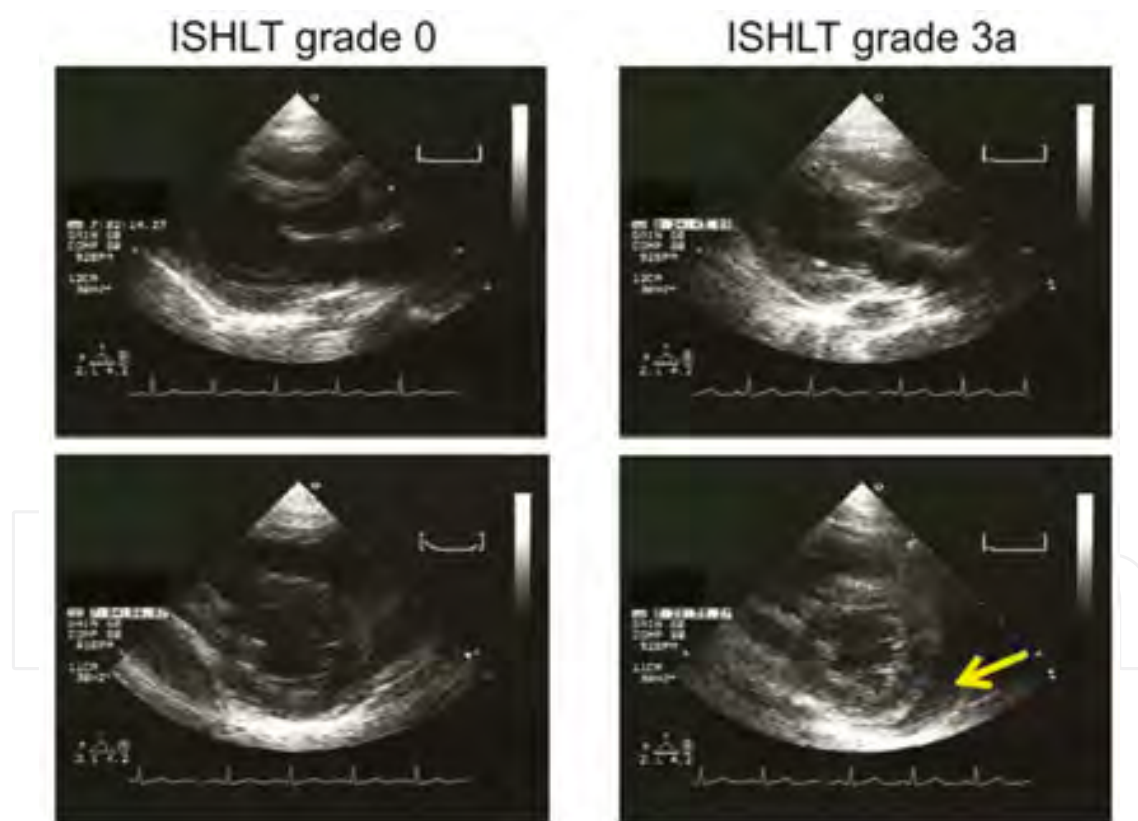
Representative 2D echocardiography in a patient with and without cellular rejection. Representative conventional 2D echocardiograms obtained from a 26-year-old female transplant recipient at the time when her EMB showed conventional ISHLT grade 0 (left) and ISHLT grade 3a rejection (right). The posterior wall thickness of LV and the LV mass index without rejection (left) were 9 mm and 88 g/m², respectively. The same parameters associated with rejection (right) were 13 mm and 112 g/m². The arrow in the right lower panel indicates a pericardial effusion. EMB, endomyocardial biopsies; ISHLT, International Society for Heart and Lung Transplantation; LV, left ventricular and left ventricle.
